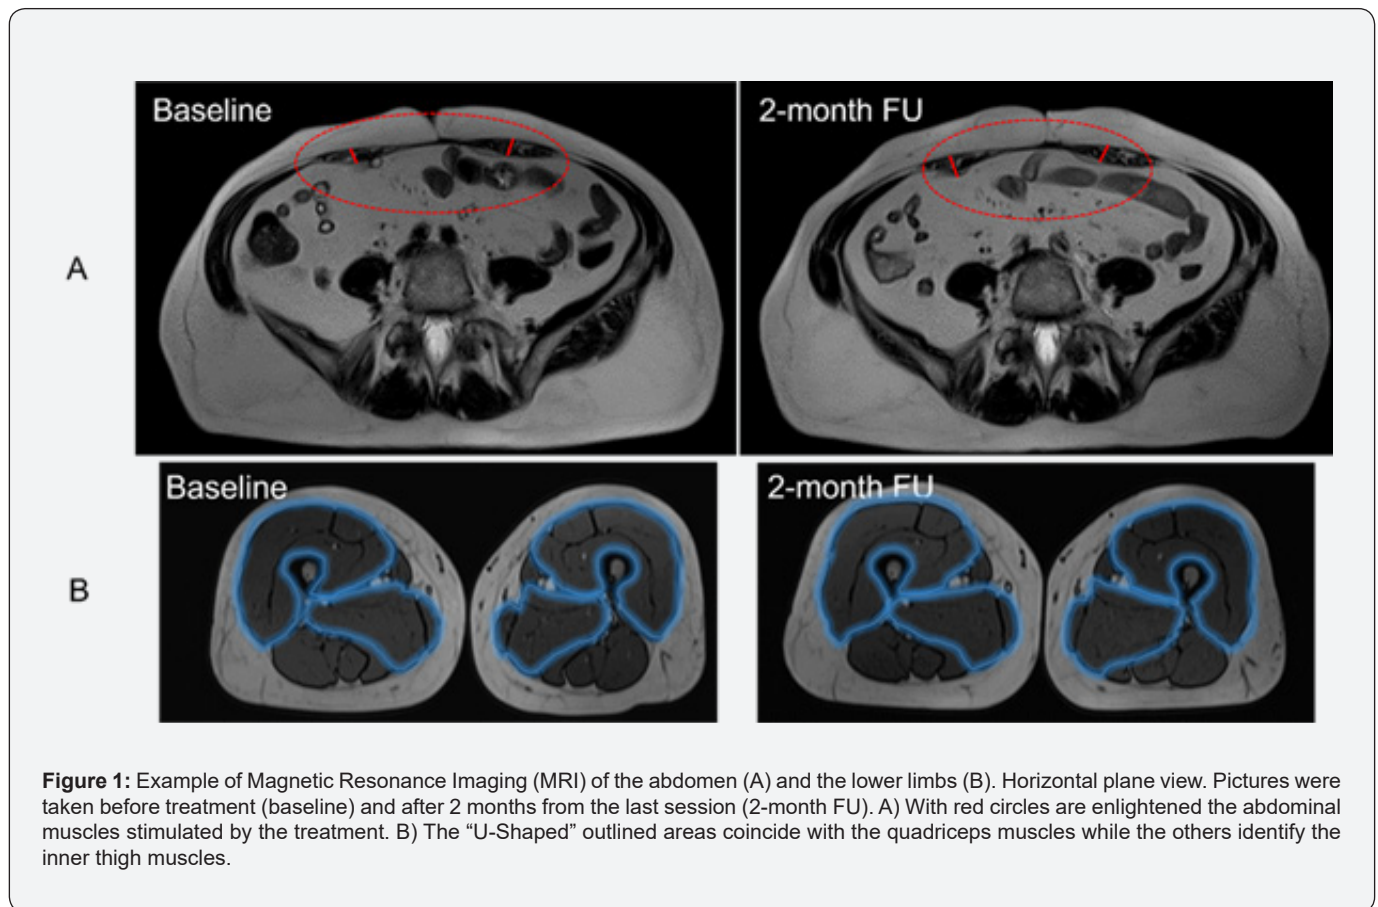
Example of Magnetic Resonance Imaging (MRI) of the abdomen (A) and the lower limbs (B). Horizontal plane view. Pictures were taken before treatment (baseline) and after 2 months from the last session (2-month FU). A) With red circles are enlightened the abdominal muscles stimulated by the treatment. B) The “U-Shaped” outlined areas coincide with the quadriceps muscles while the others identify the inner thigh muscles.
